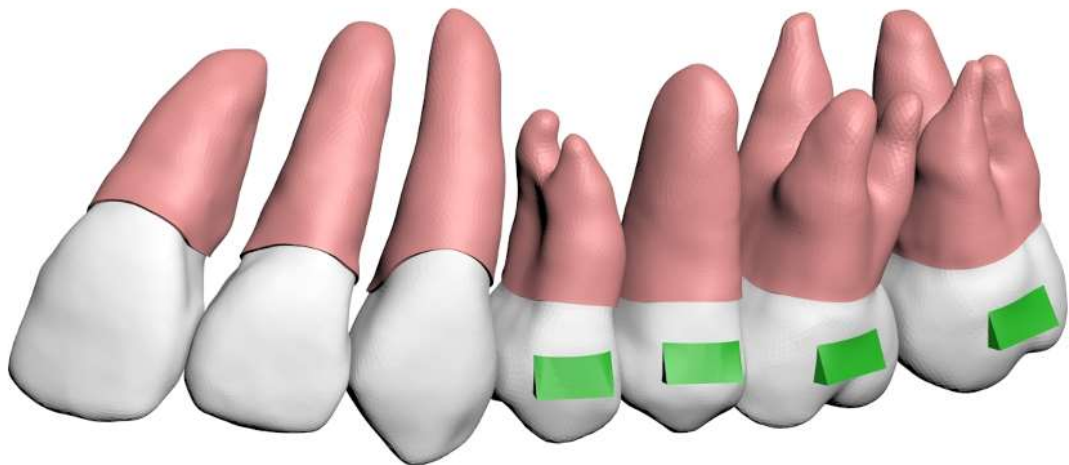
Phase 1 Model 1.1: Segmented teeth from CBCT with Periodontal Ligaments
